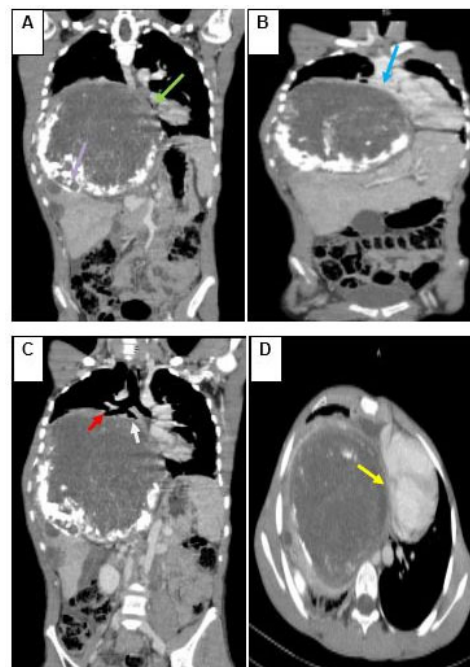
Thoracic-abdominal CT scan with iodinated contrast injection, coronal (A, B, C) and axial (D) sections: Right lung mass located in the lower and middle lobes, well limited, evenly contoured, hypodense, heterogeneous, containing calcifications: (A) It exerts a mass effect on the esophagus with reduction of its lumen without clear interface (green arrow). (B) It laminates the right pulmonary vein (blue arrow).
